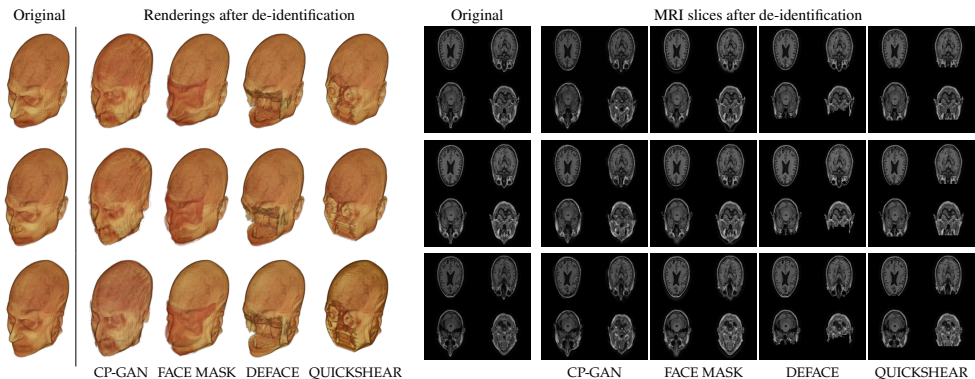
De-identification examples*: De-identified face renderings (*left*) and the corresponding MRI scans (*right*) for several examples from OASIS-3. All methods perfectly preserve the brain, but only CP-GAN successfully de-identifies the patient while maintaining realistic appearance and structure.
